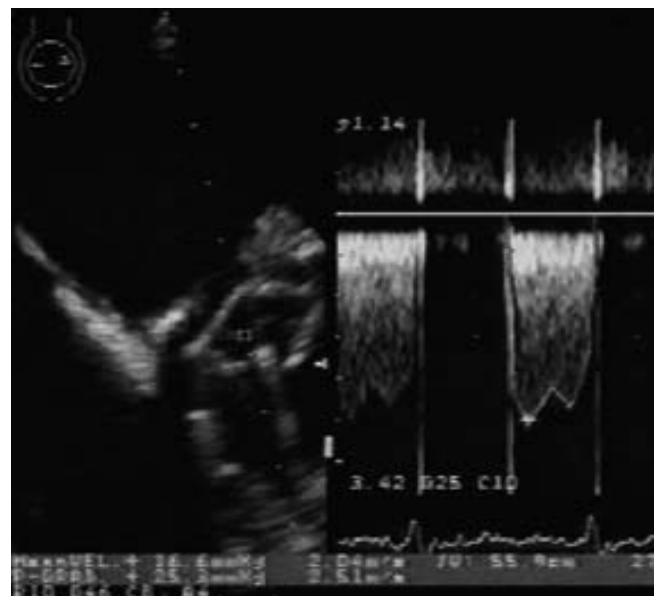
Continuous-wave Doppler echocardiography of the mitral prosthesis, showing a mean gradient of 16 mmHg.
